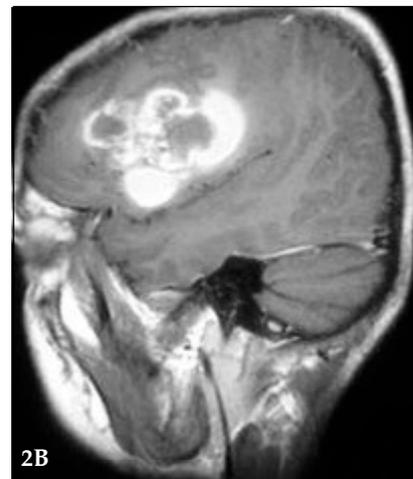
A-B: Non-enhanced axial and sagittal T1-weighted images (2A-2B) revealing hypointense lesions with peripheral hyperintensities at the left fronto-parietal region and subacute hemorrhage medially surrounding these lesions.
